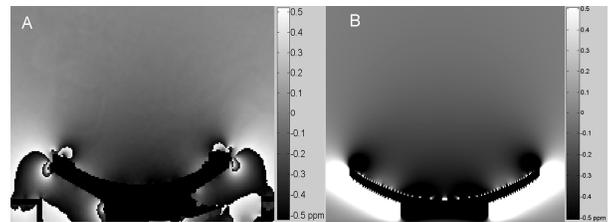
ultrasound applicator induced delta magnetic field. A) by measurement, B) by calculation. Phase wrapping can be observed around the applicator due to large magnetic field variation (A).
